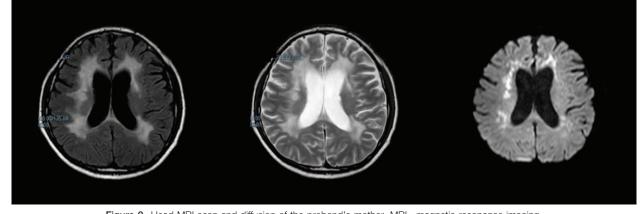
Head MRI scan and diffusion of the proband's mother. MRI=magnetic resonance imaging.
